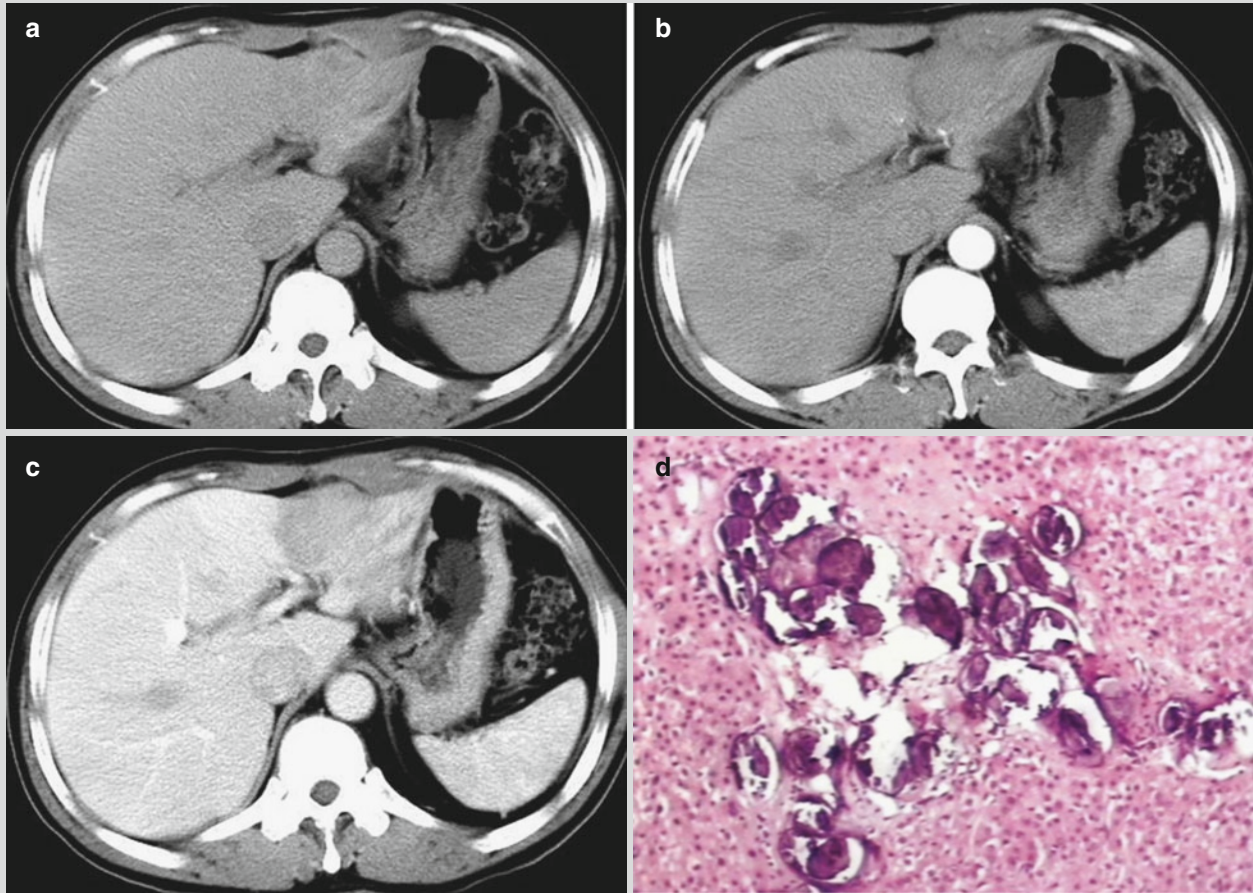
Hepatic schistosomiasis. (a) Plain CT scanning demonstrates uneven low-density shadows in the left liver with poorly defined boundaries. (b, c) Contrast CT scanning demonstrates mildly
